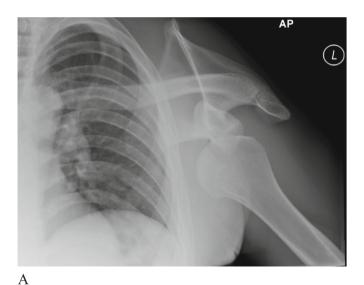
Fig. 1A – AP radiograph of patient's left shoulder at first presentation showing anterior dislocation. Also note degree of scapular dyskinesia. Fig. 1B – Scapular Y view radiograph of patient's left shoulder at first presentation showing anterior dislocation.
